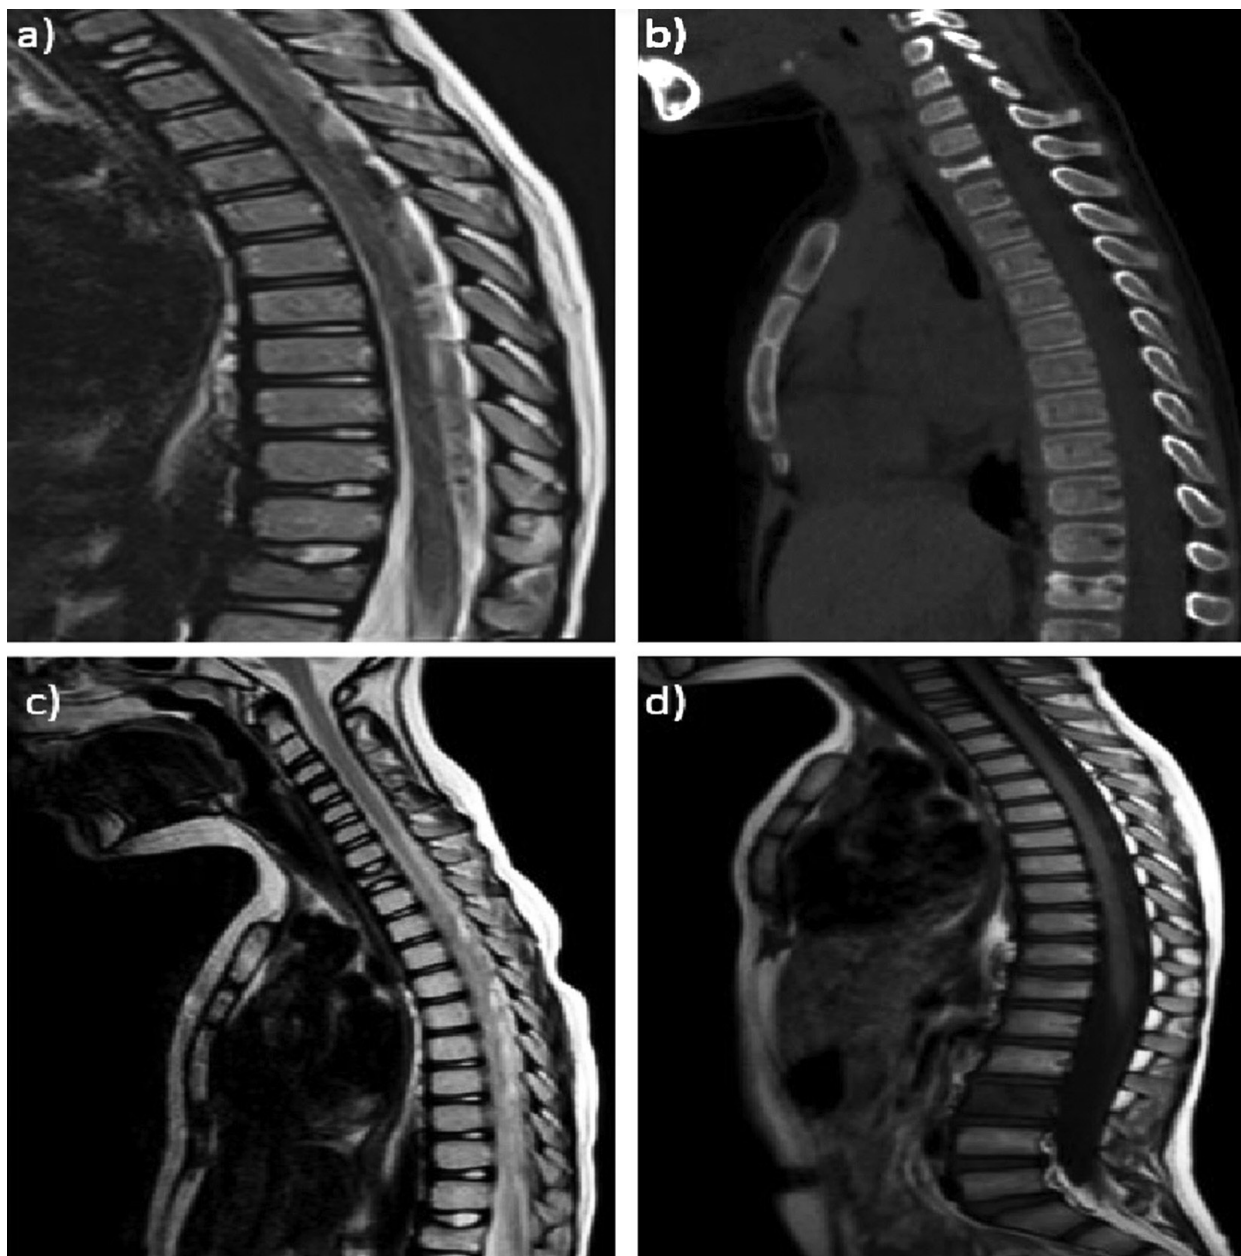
Radiological imaging of a 9-year-old female patient with T1 and T12 vertebral bone involvement a,b) MRI and CT were taken when the patient presented with back pain. There is height loss in the T1 and T12 vertebral bodies. c) T2 sequence of MRI of the patient was taken three months after chemotherapy treatment started. d) MRI of the patient was taken 18 months after the start of chemotherapy treatment, there is a hypointense signal in the L3 vertebra in the sagittal T1 sequence. It was considered a recurrence.
